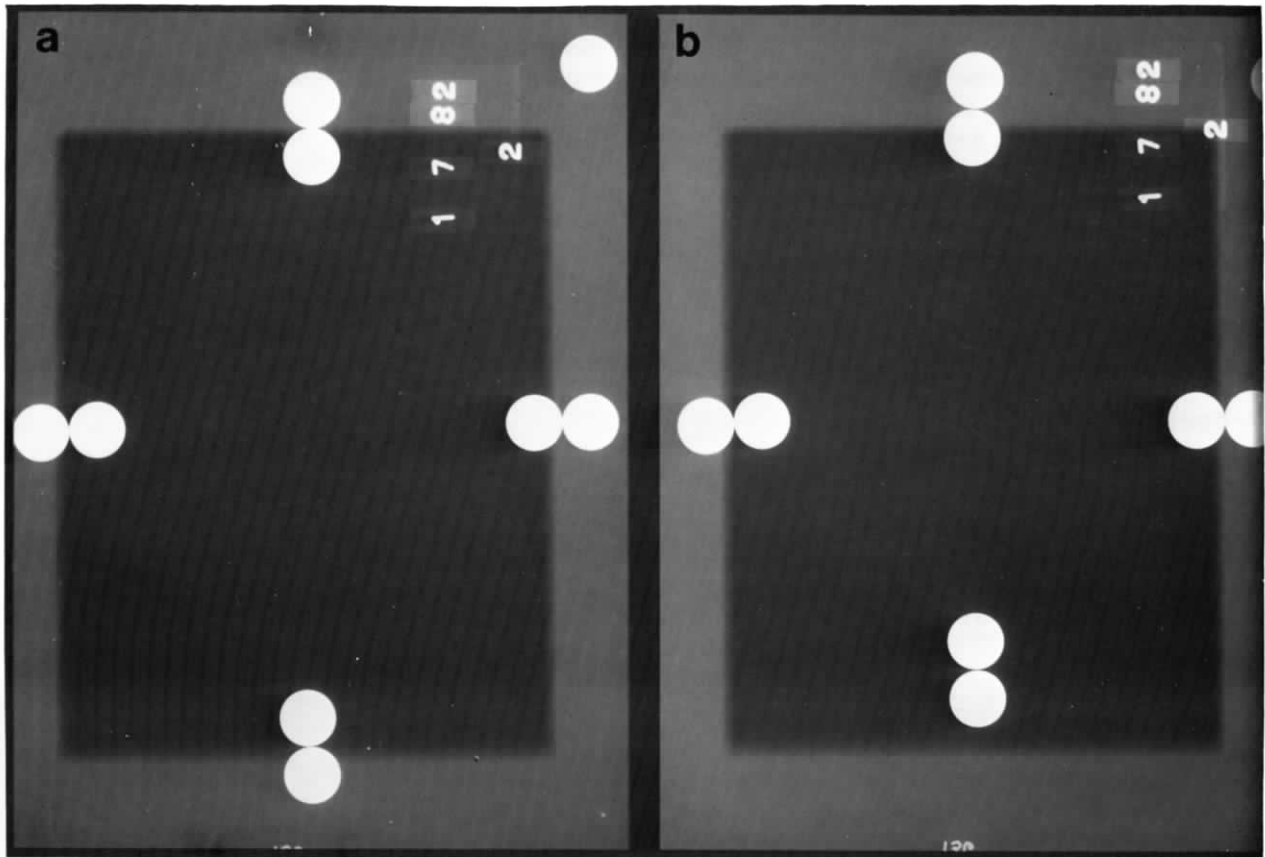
X-ray field-light field congruence test results. These radiographs should show the date, room number, and pennies. (a) Results where the x-ray field falls within half of a penny's distance from the center line are ideal. (b) If any side of the x-ray field exceeds the proper location by more than one penny (e.g., at the bottom of this image) a service engineer should adjust the collimator.
